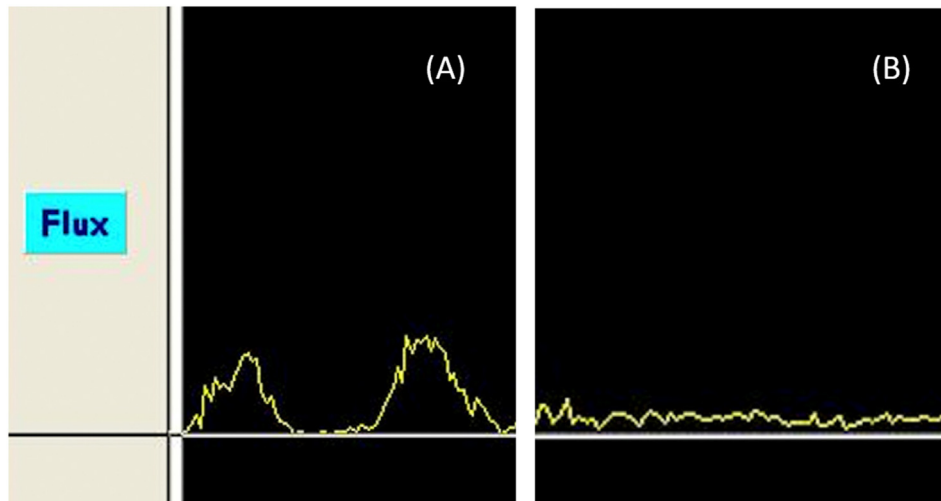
Waveforms of the laser Doppler imager. (A) Normal pulp. (B) Necrotic pulp.
